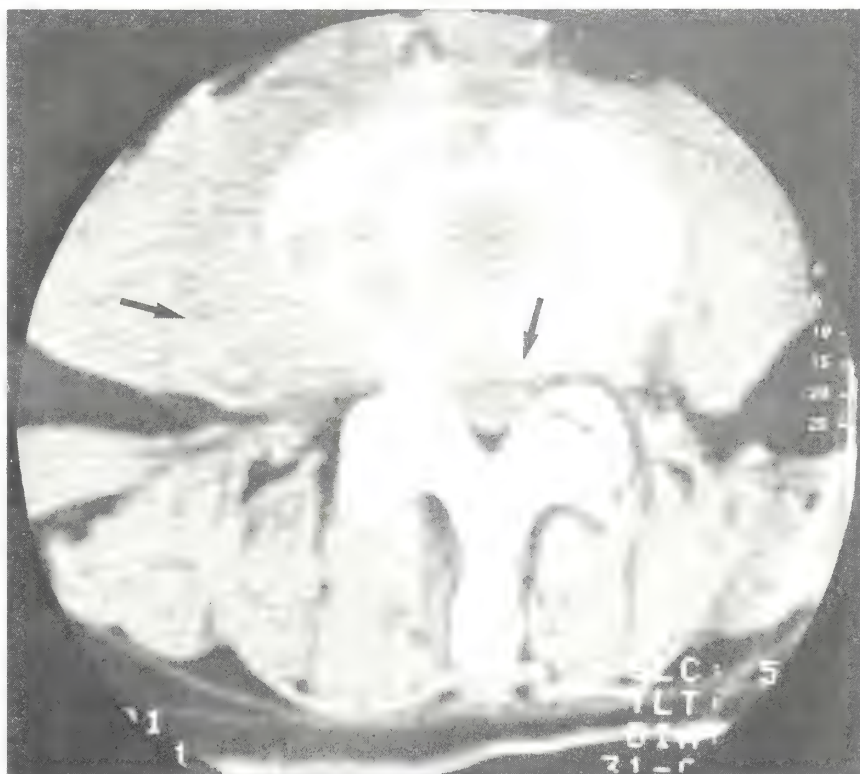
CT confirms the MRI findings of endplate destruction with paravertebral and epidural extension of the mass (arrowheads).
